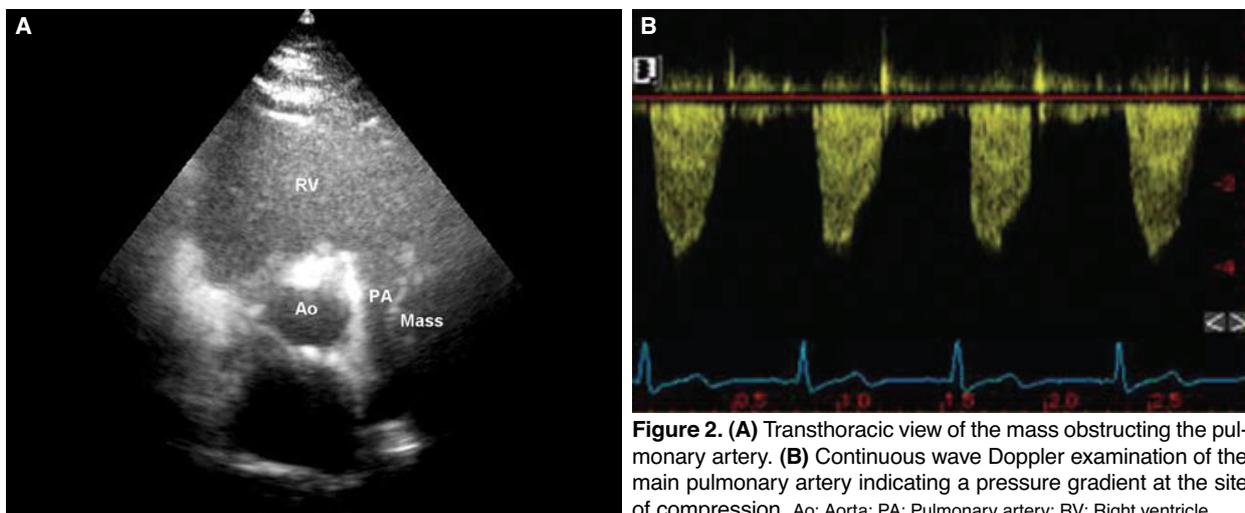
(A) Transthoracic view of the mass obstructing the pulmonary artery. (B) Continuous wave Doppler examination of the main pulmonary artery indicating a pressure gradient at the site of compression. Ao: Aorta; PA: Pulmonary artery; RV: Right ventricle.
